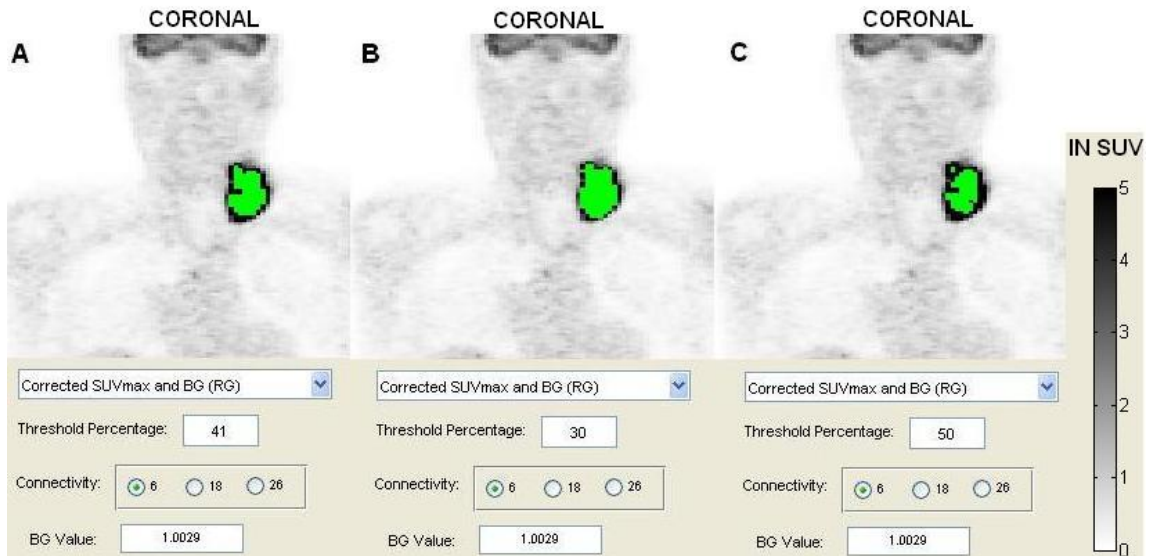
Visual Display of Background Subtracted SUV_{max} Segmentations
